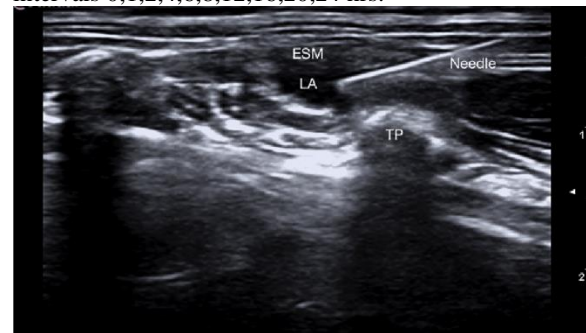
Ultrasound image of erector spinae block
